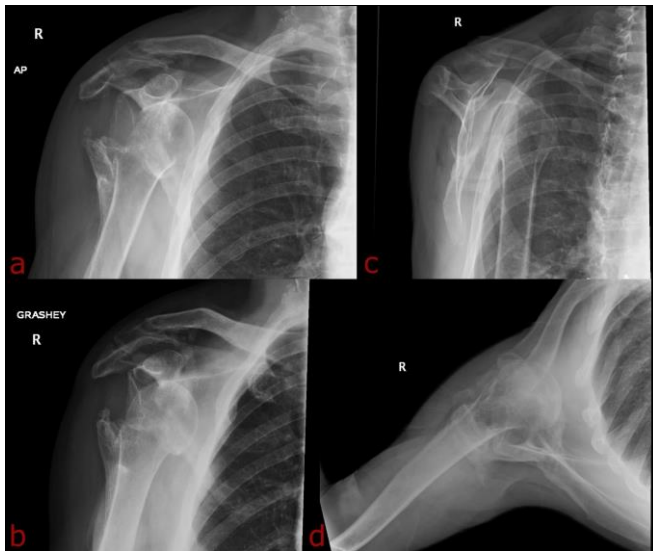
Right shoulder radiographs taken at the patient's initial visit to our clinic, demonstrating anterior shoulder dislocation. Views: (a) anterior-posterior [AP], (b) Grashey, (c) Scapular-Y, (d) Axillary.
